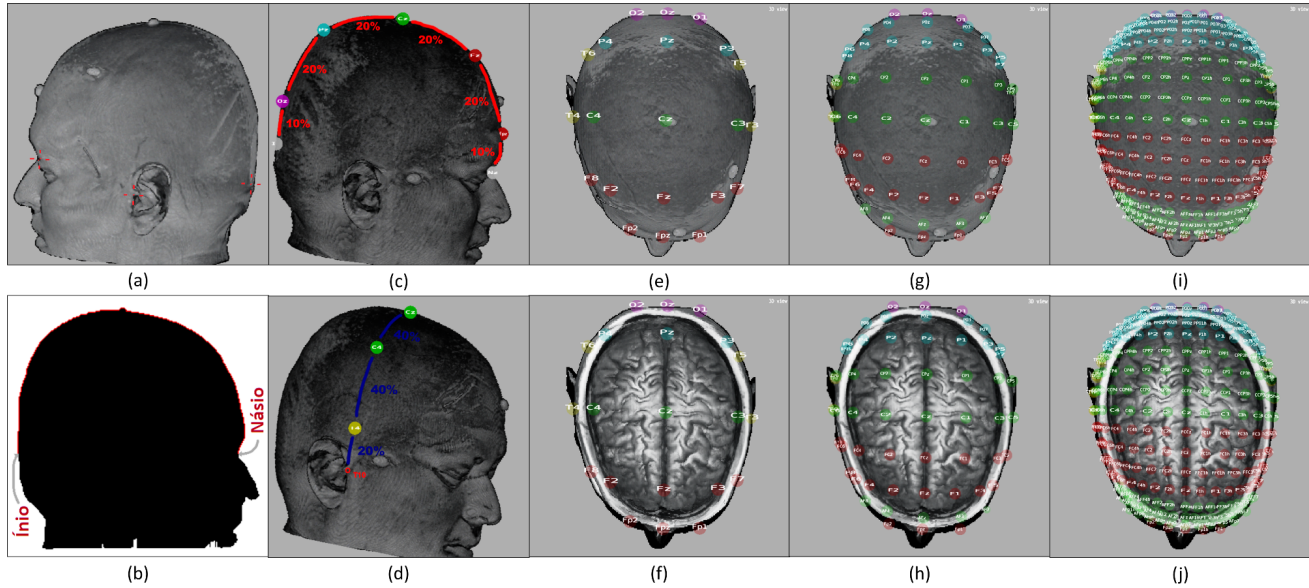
Primary reference points, nasion, inion and preauricular ones, are selected on the T1-weighted magnetic resonance volume. They are indicated with a red hair-cross (a). Then, the slice of the head on the midsagittal plane is segmented (b) and the sagittal central reference curve determined (c). This reference curve is divided from nasion to inion in fractions specified by the international system (d). Other reference curves are set in sequence. The locations of EEG electrodes affixed on the scalp in accordance with the international 10/20 (e), 10/10 (g) and 10/5 (i) system are automatically determined. By adjusting the opacity of the cranial bone marrow the correspondences between the electrodes and the cerebral structure is visualizable (f, h and j).
